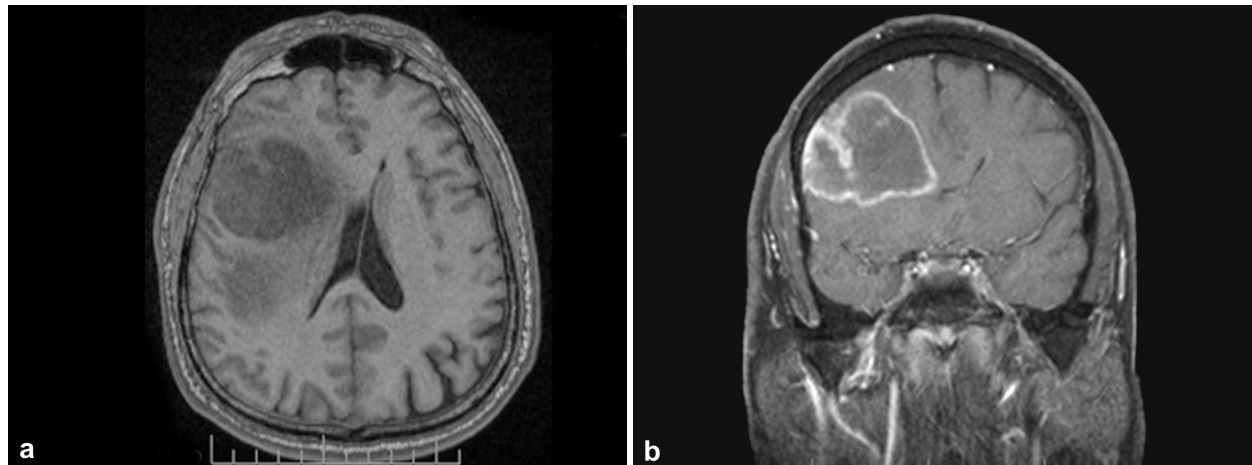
Preoperative brain MRI scan with gadolinium: axial T1 (a) and sagittal T1 (b) showed a left large irregular fronto-insular mass with central necrosis and a nodular zone.
